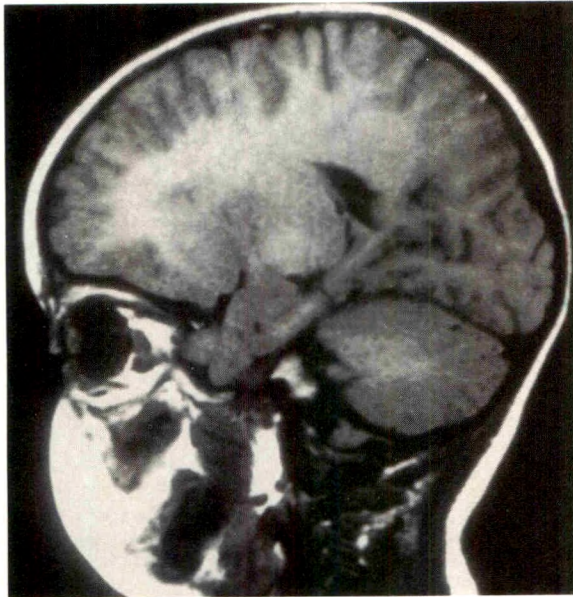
(Imes and Hoyt). Case 4. T₁-weighted parasagittal magnetic resonance image of the left orbit. The optic nerve is tubularly thickened, elongated, and kinked downward in the midorbit. An area of low signal intensity surrounds a core of higher signal intensity.
